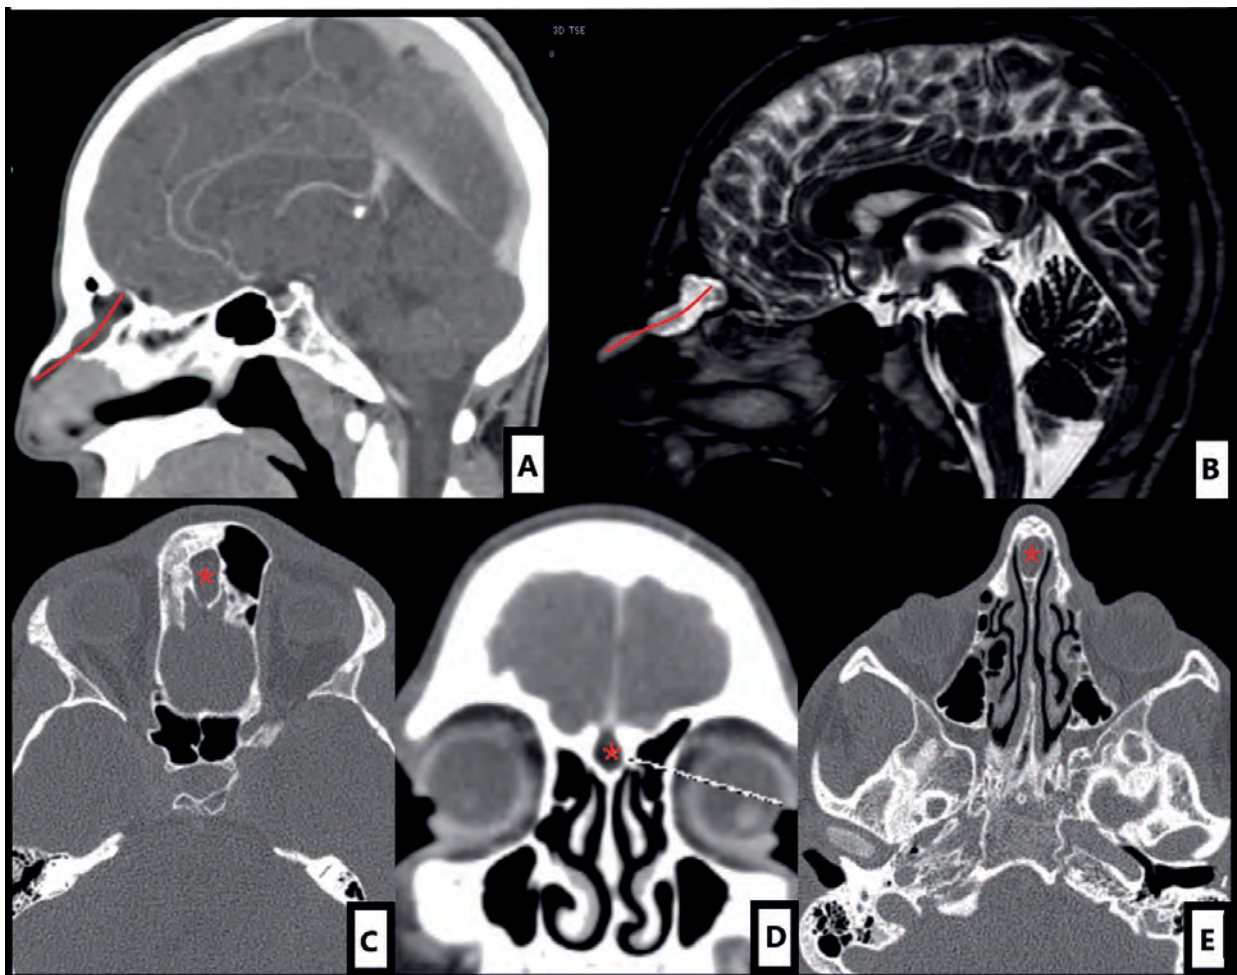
Preoperative computed tomography (CT) scan and magnetic resonance imaging (MRI). The red line shows the tract of the cyst, from the nasal dorsum through a foramen caecum into a bifid crista galli (intracranial component), in a sagittal view of a CT scan (A) and a MRI (B). Red asterisk shows the superior limit of the cyst in the bifid crista galli in an axial (C) and coronal (D) plane of the CT scan. In addition, red asterisk shows the perpendicular plate of the ethmoid remodelled by the cyst in an axial plane (E) of the CT scan.
